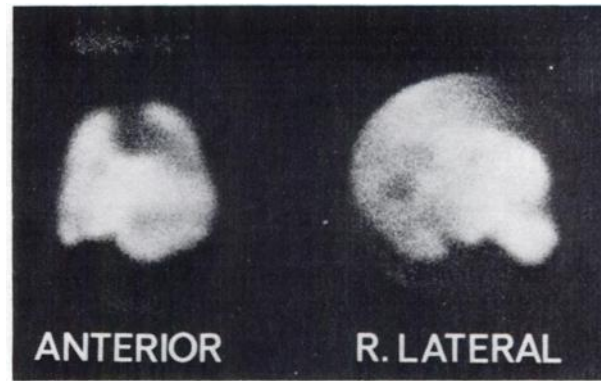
Liver scintigram in Patient 3 shows hepatomegaly with multiple areas of decreased tracer uptake; also marked shift of radiocolloid to lung.
